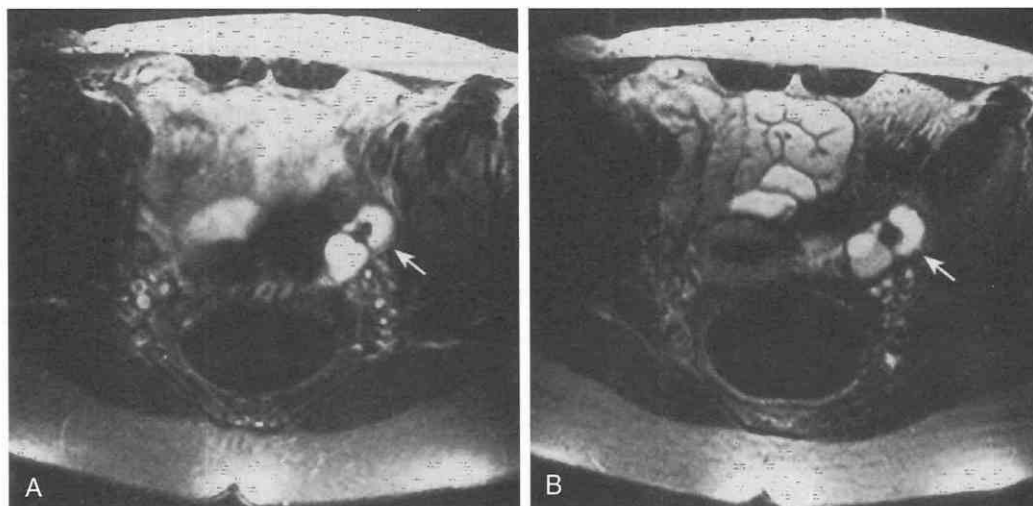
Use of glucagon to suppress motion artifact. Axial T2-weighted, fast spin-echo images (TR = 4000 msec, TE_{eff} = 12 msec) before (A) and after (B) intravenous administration of 0.1 mg glucagon. Glucagon improves the definition of the bowel wall and also results in fewer ghosting artifacts in the phase-encoding (right-to-left) axis. The septate high-signal-intensity left ovarian mass (arrow) with a central low-signal-intensity mural nodule proved to represent a cystadenofibroma. TE_{eff}, effective echo time.
